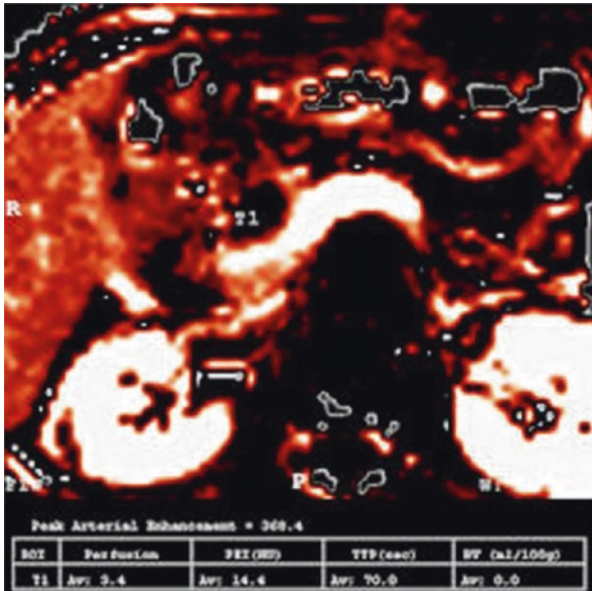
Perfusion CT scan of the ablated area (in T1 the blood flow is zero)
